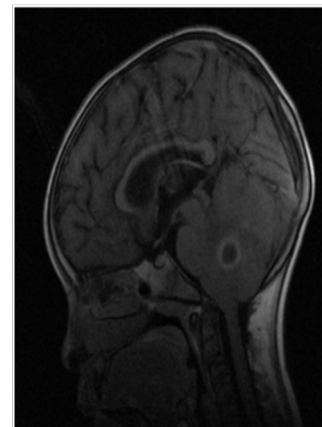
MRI showing the cerebellar abscess.
